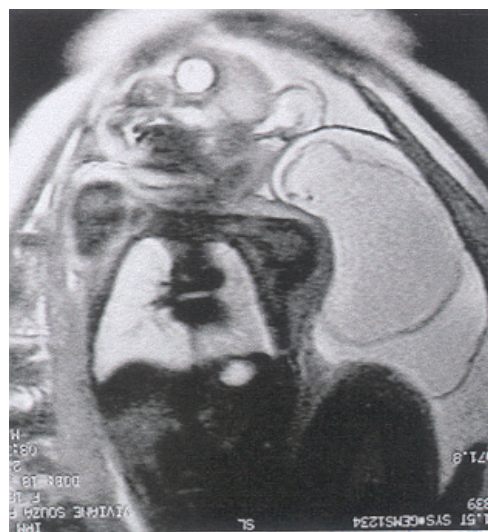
Coronal view T2w MRI scan at 35 weeks of gestation demonstrating a occipital encephalocele in a case of Chiari III.
